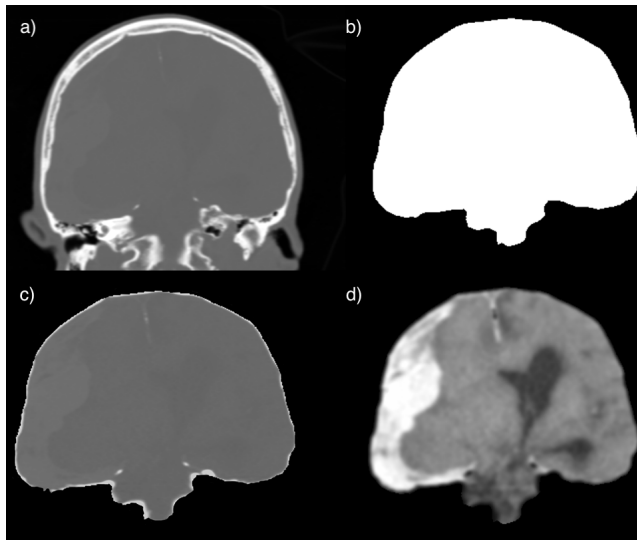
Cerebral segmentation process. The segmentation process consisted of 3D CT datasets. a) Original CT image in the coronal plane, b) 2D view of the created binary mask with the FSL library, c) segmented CT image in the coronal plane, d) contrast enhanced CT image in the coronal plane. (picture: A. Zirn)
